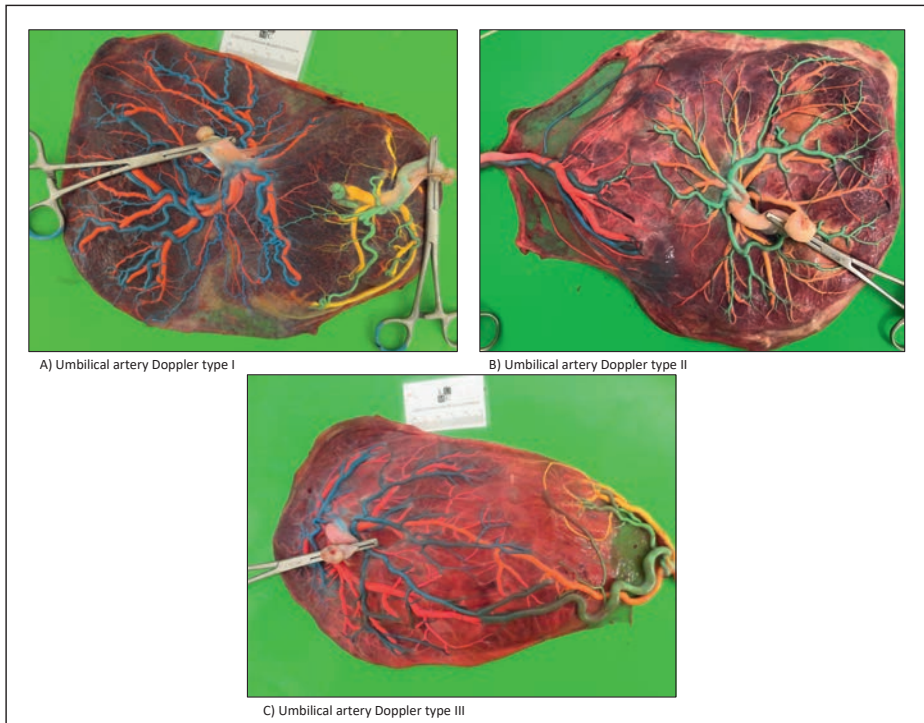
Pictures of injected placentas of pregnancies with sFGR with UA Doppler type I (A), type II (B) and type III (C). Type I demonstrates a small AA anastomosis. In type II the diameter of the AA anastomosis is slightly larger. Type III shows the largest diameter.
